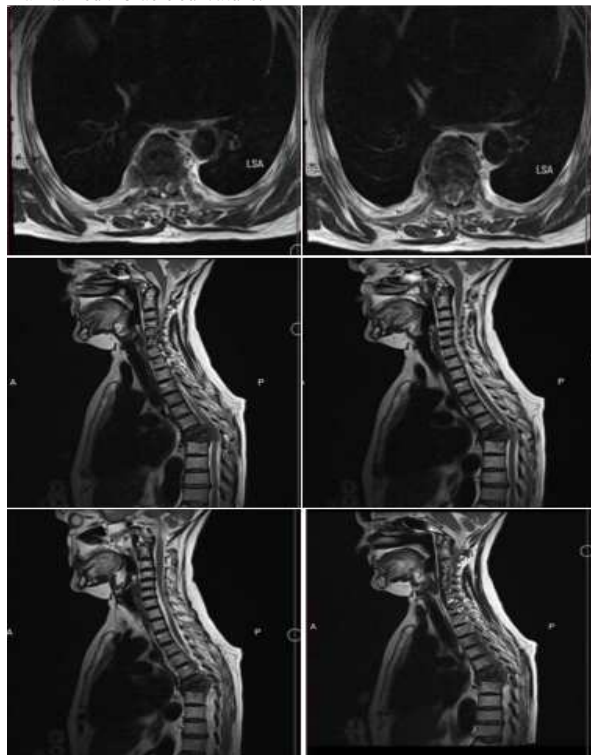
MRI T2WI of 32 Y/M showing D7-D8 collapsed vertebra with pre and para vertebral collection with cord compression and Kyphosis Axial and sagittal view
